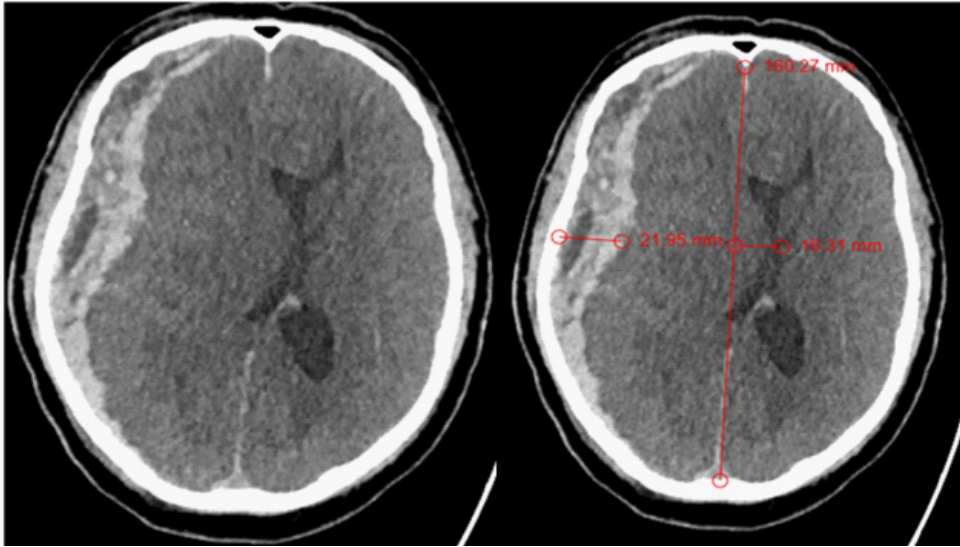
Axial view of non-contrasted enhanced CT scan showing a large, crescent-shaped extra-axial collection seen along the right cerebral convexity, demonstrating a mixed density pattern with areas of both hyperdensity and hypodensity. The collection measures approximately 21 mm in maximal thickness. There is effacement of the right cortical sulci, indicating significant mass effect on the adjacent brain parenchyma. Partial effacement of the right lateral ventricle noted, with compression of the frontal horn and body of the lateral ventricle. There is a leftward midline shift measuring approximately 16 mm, with displacement of the septum pellucidum.
